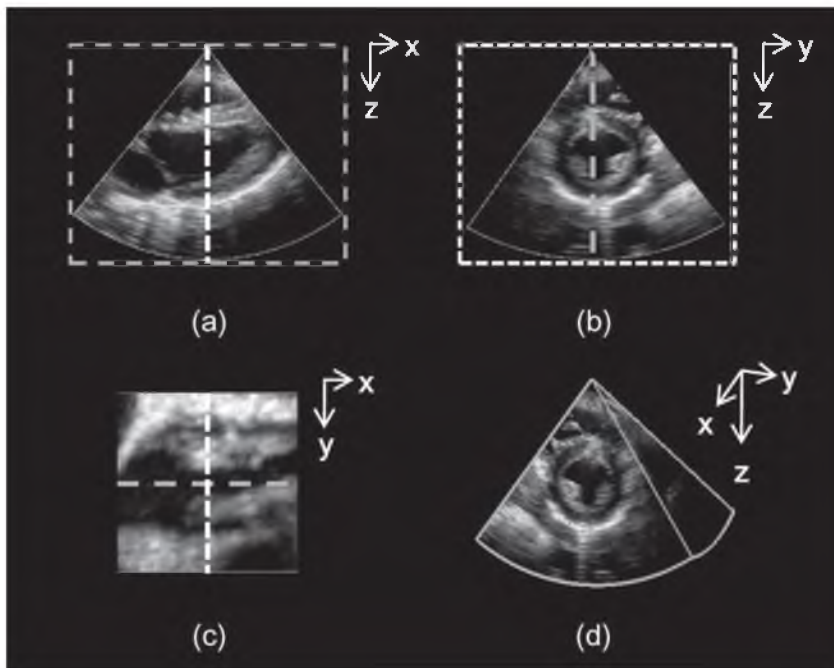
Example of 3D ultrasound data of the left ventricle; a) long-axis view; b) short-axis view; c) short/long-axis slice through the middle of the left ventricle; d) 3D volume rendering.
